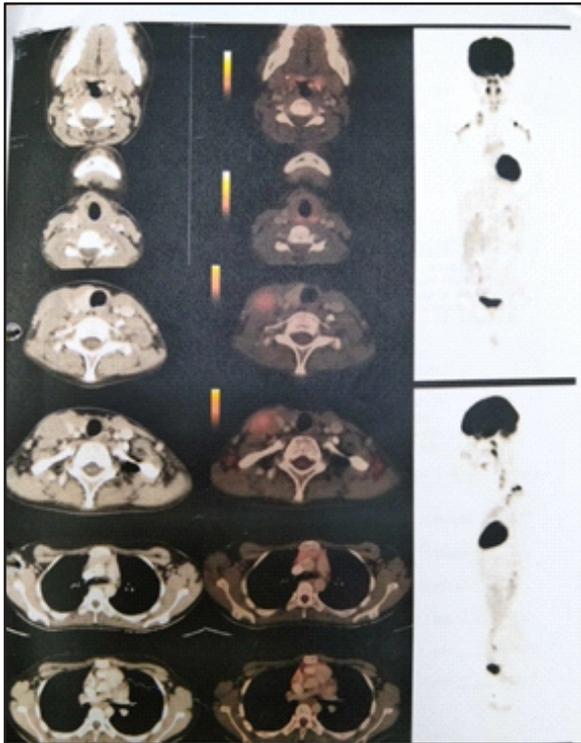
PET CT Images of patient
